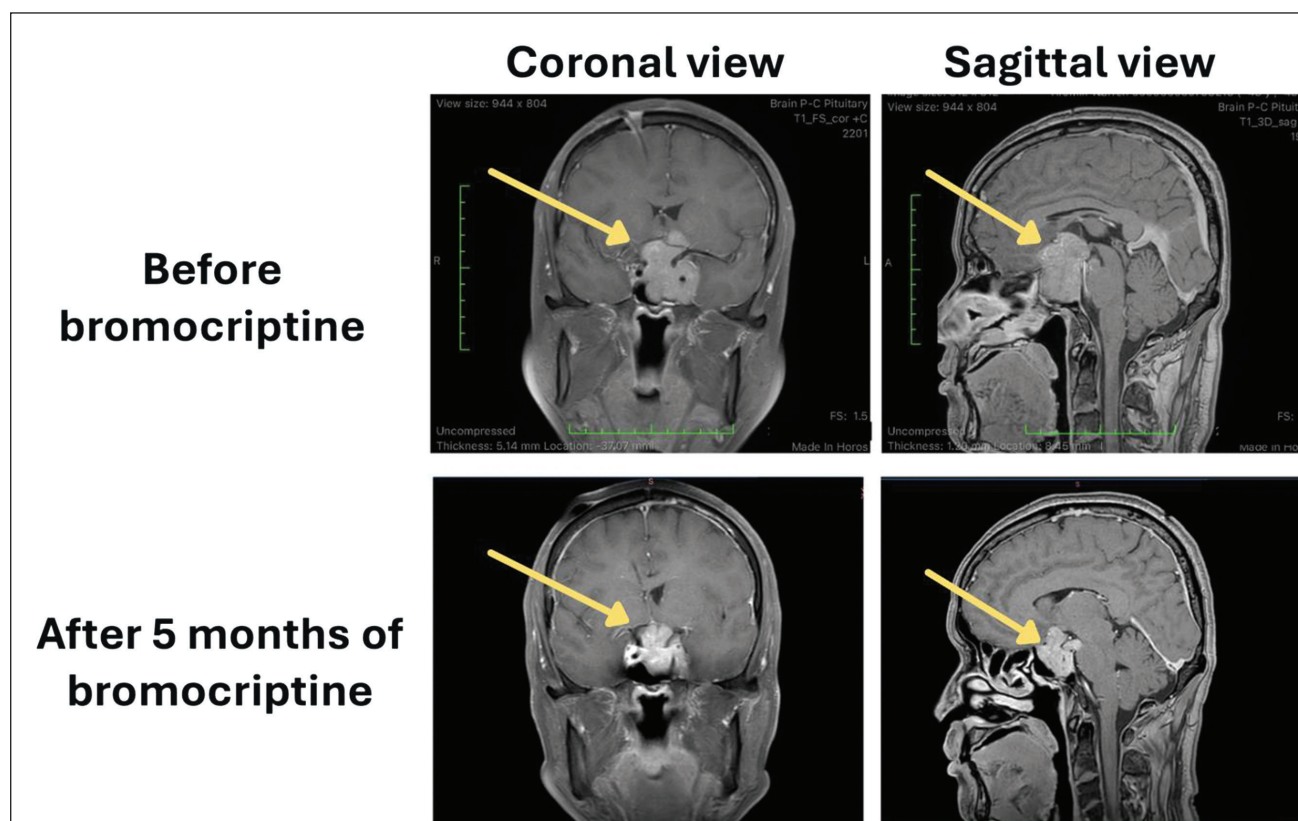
MRI showing the giant pituitary adenoma (arrows) before and 5 months after starting bromocriptine treatment.
